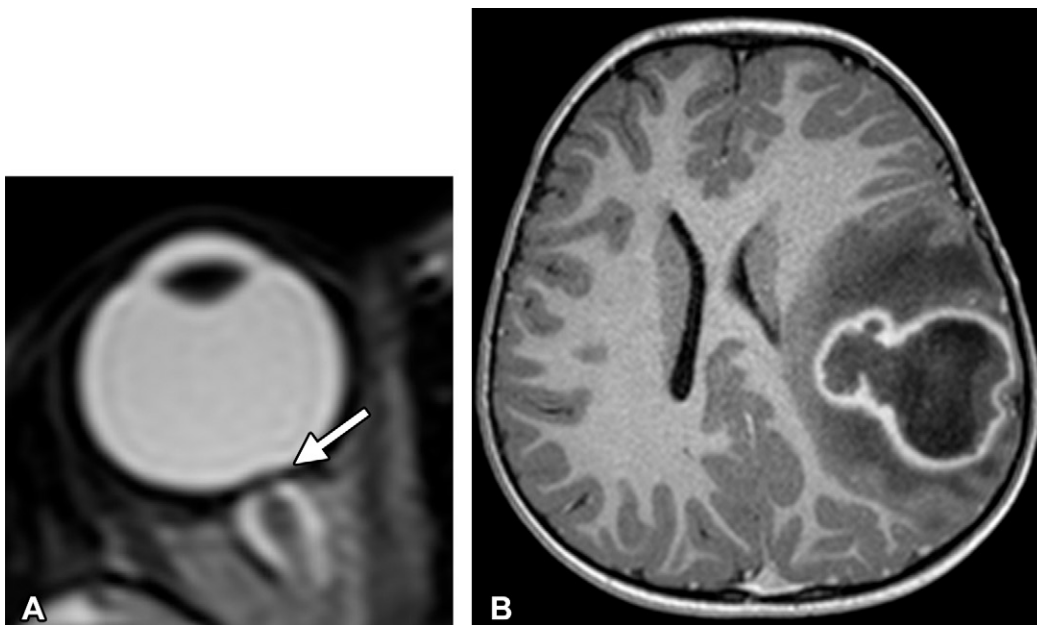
Papilledema secondary to a large cerebral abscess and associated elevated intracranial pressure in a 3-year-old patient. (A) Axial T2-weighted (T2W) FS MR image shows flattening of the posterior globe with subtle elevation of the ON head (arrow) and distention (>7.5 mm) of the ON sheath. (B) Axial contrast-enhanced T1W MR image of the brain shows a large peripherally enhancing abscess in the left frontoparietal region, with surrounding T1-hypointense vasogenic edema. The abscess showed corresponding marked restricted diffusion (not shown).
